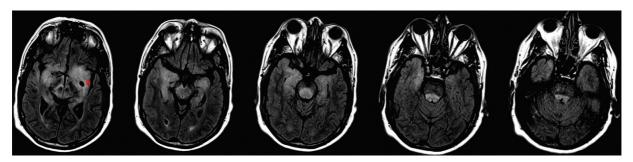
T2/FLAIR hyperintensities extend into the mesial temporal lobes, midbrain, periaqueductal gray, and dorsal pons. Additionally, a dilated perivascular space is noted (asterisk).
